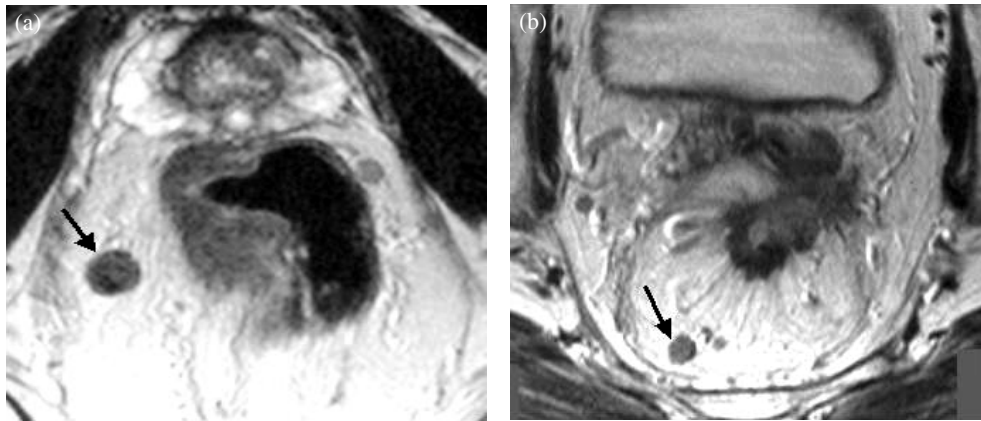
(a) and (b) Rectal cancer. Two patients with advanced disease showing enlarged ill-defined irregular lymph nodes. Note: both nodes (arrows) have a heterogeneous signal intensity on these T2-weighted images.
